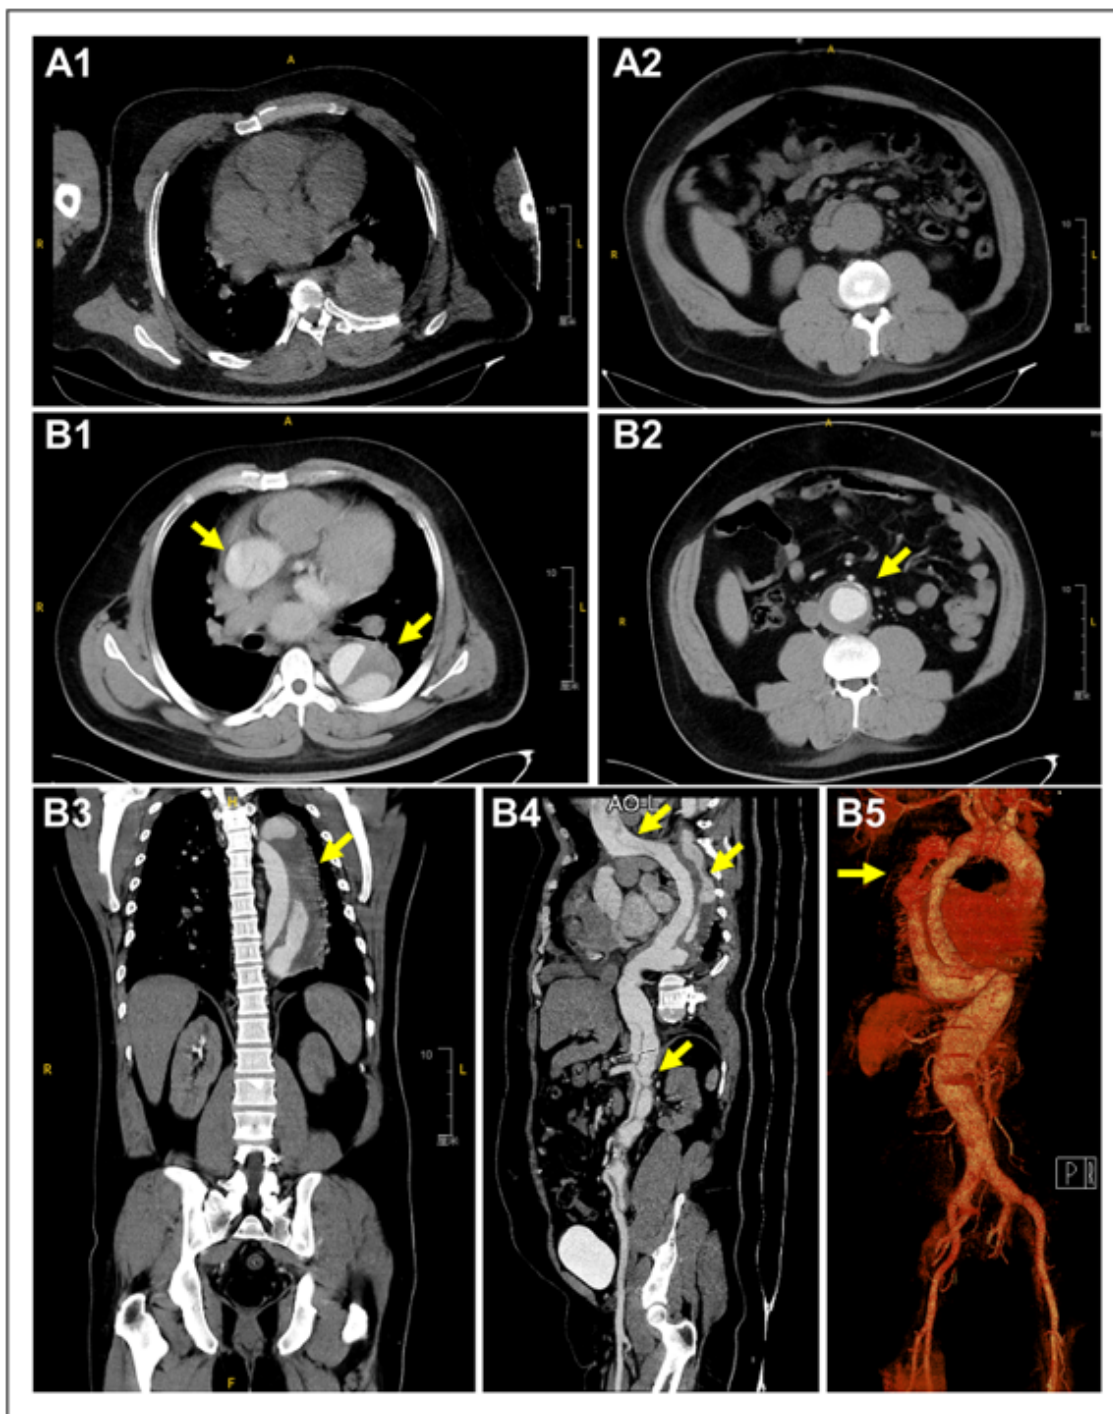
Radiological findings of thoracoabdominal CT scan and thoracoabdominal aorta CTA. A1-A2. Thoracoabdominal CT scan revealed a dilated thoracoabdominal aorta with heterogeneous intraluminal density, suggestive of aortic dissection. B1-B5. Thoracoabdominal CTA cross-sectional images (B1-B4) and the corresponding 3D reconstruction (B5) revealed the presence of a Stanford type A aortic dissection, characterized by the separation of the aortic wall layers.
